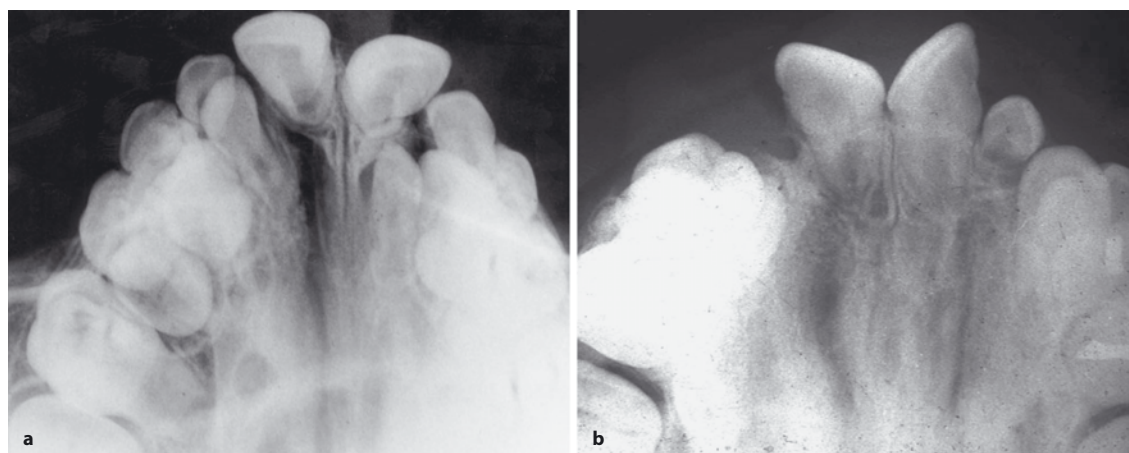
a Palatal radiograph of a patient with complete bilateral cleft lip and palate who was conservatively treated at birth with a head bonnet with an elastic strip over the protruding premaxilla. The premaxillary vomerine suture was still open
